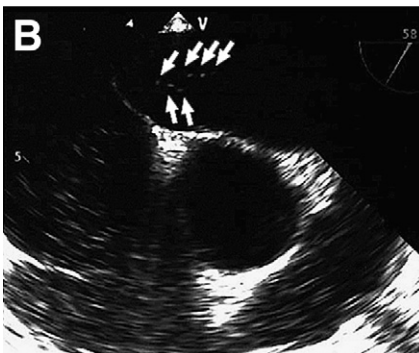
Magnetic resonance imaging with and without gadolinium enhancement revealed that there were high-intensity areas in the right cerebellum, right occipital lobe, and left thalamus on diffusion-weighted imaging (A). The contrast studies using agitated saline with Valsalva maneuver show a large shunt from patent foramen ovale and atrial septal aneurysm on transesophageal echocardiography (B).
